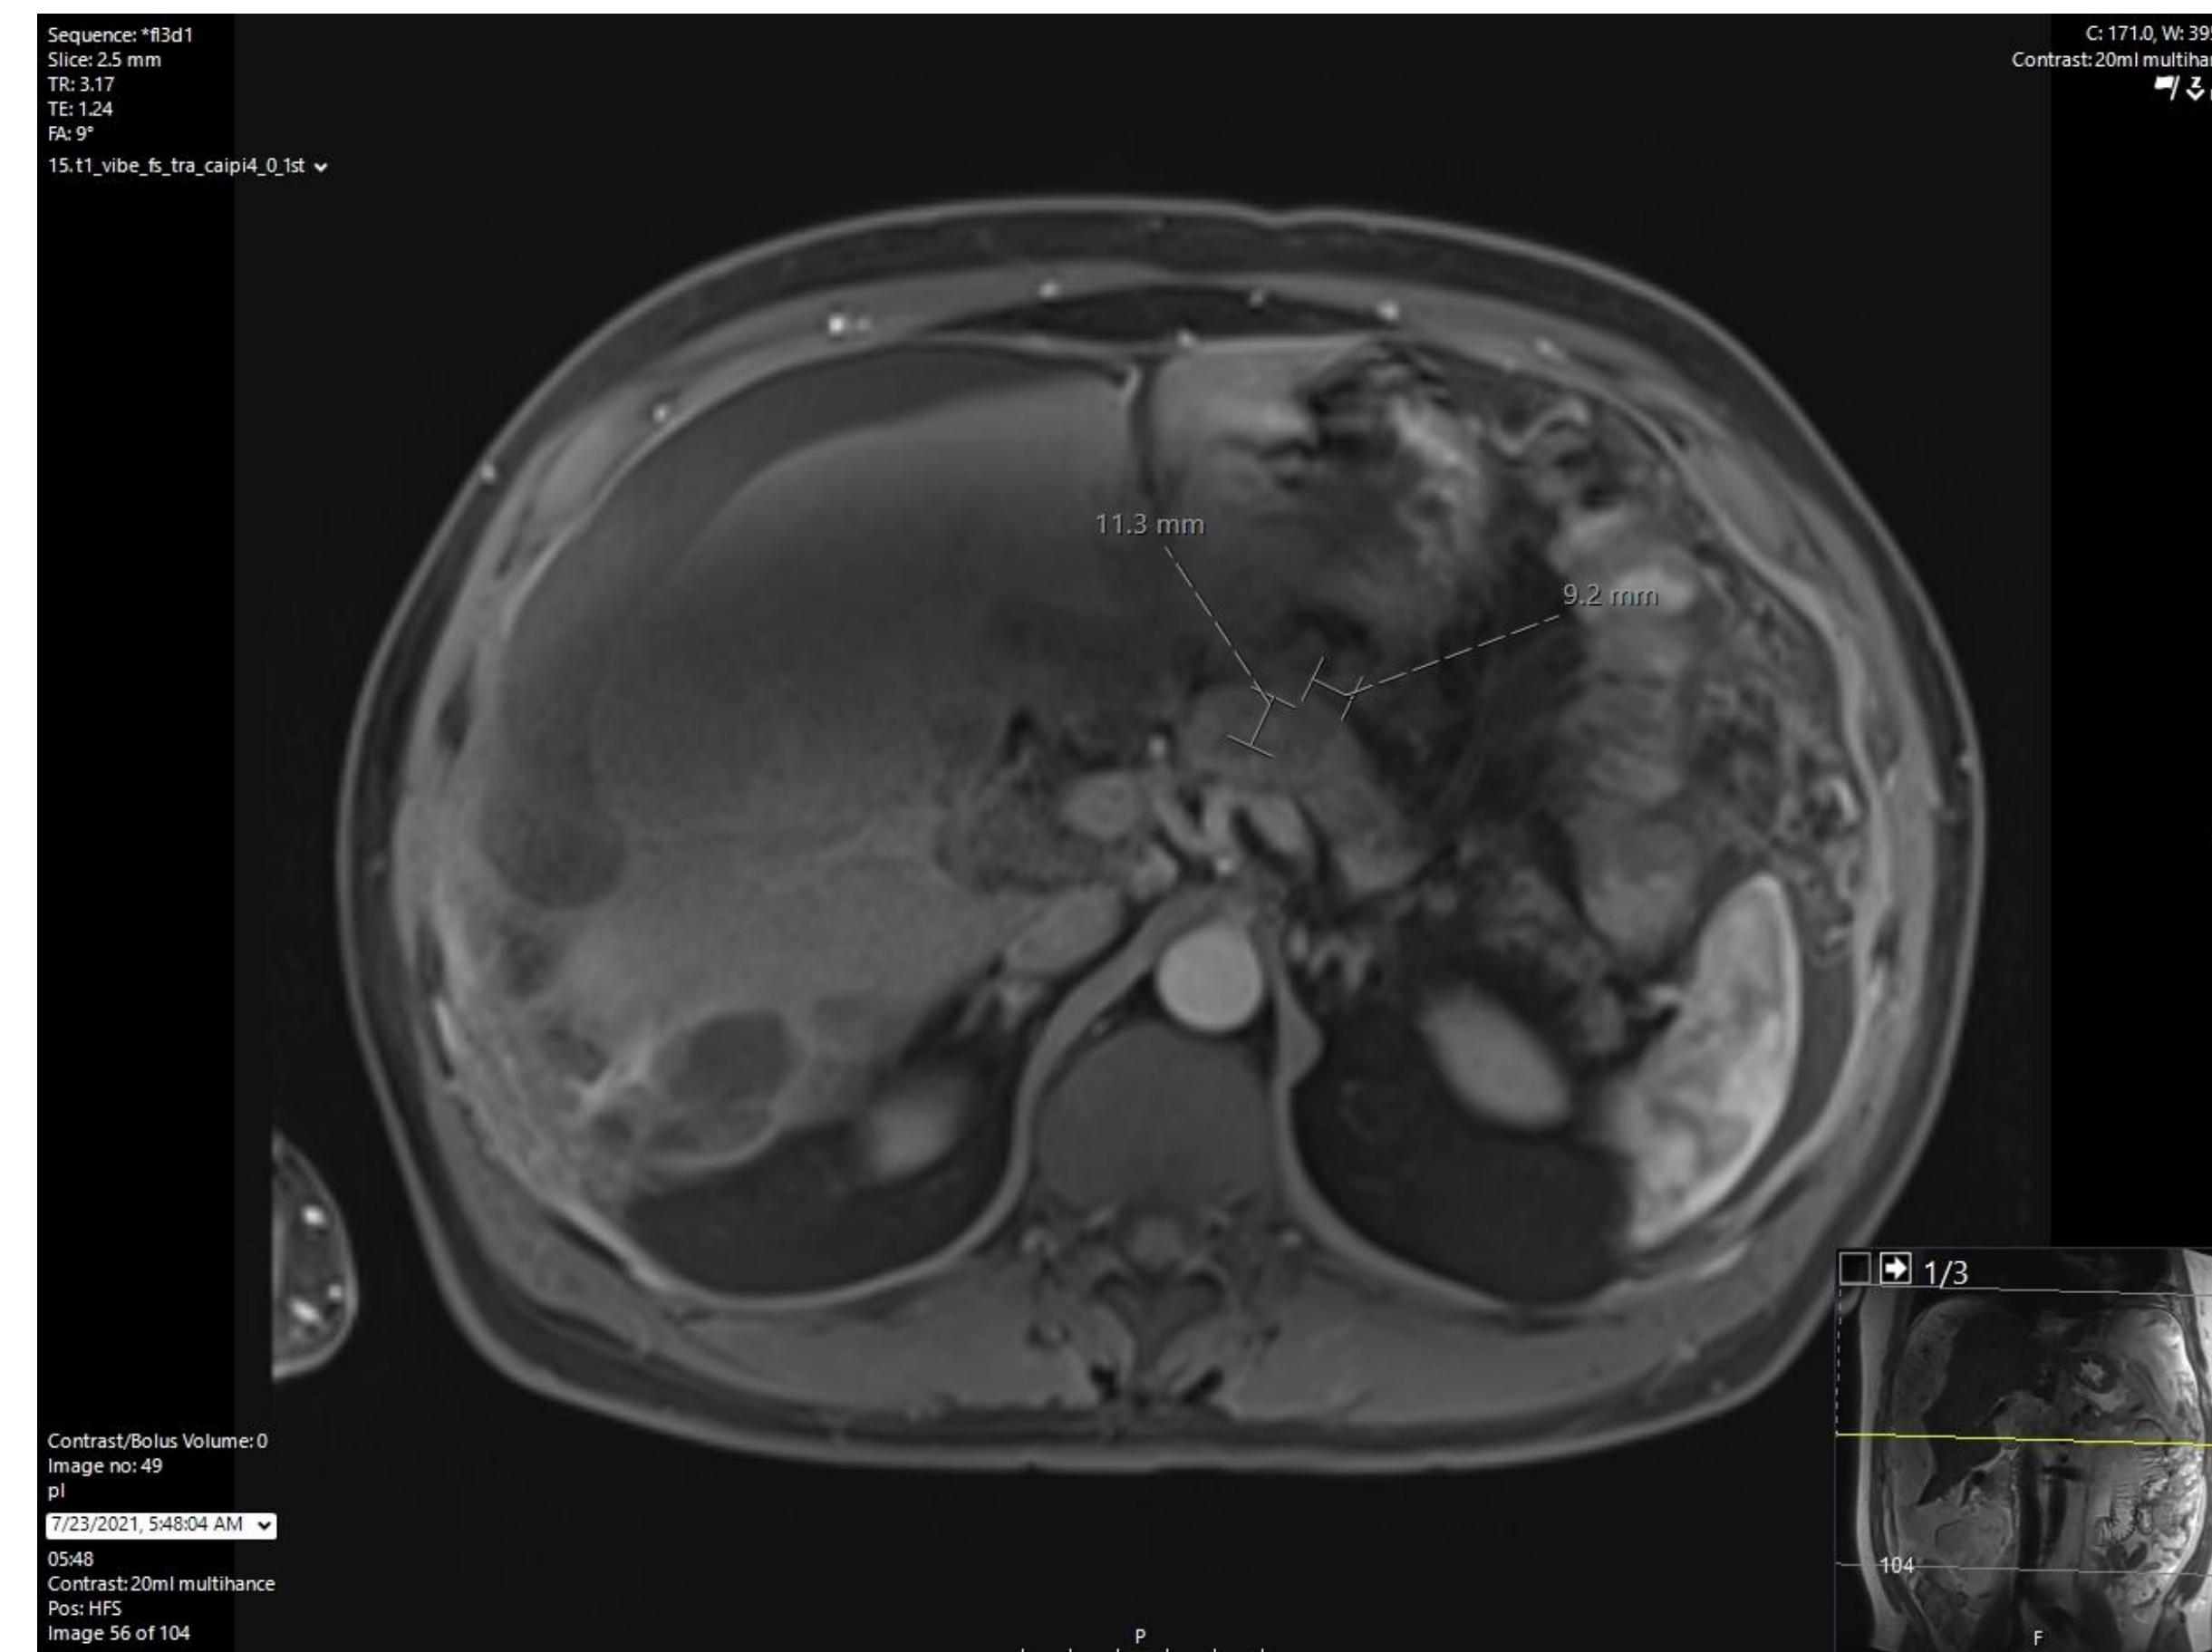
MRI revealed lesion in the body of the pancreas
